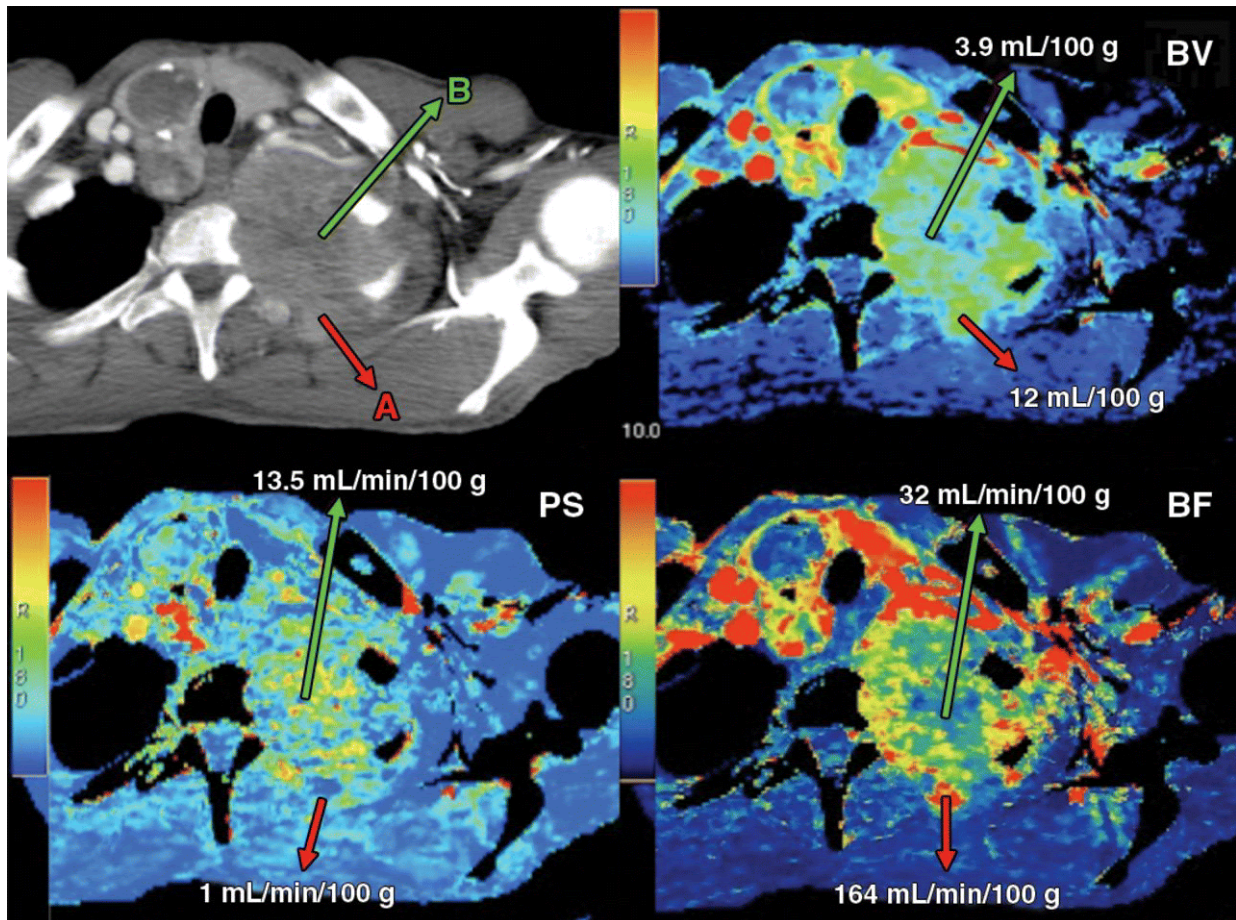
(top left) A conventional CT image, (top right) CT parametric map of blood volume or BV, (bottom left) CT parametric map of permeability-surface area product or PS and (bottom right) CT parametric map of blood flow or BS [132].
